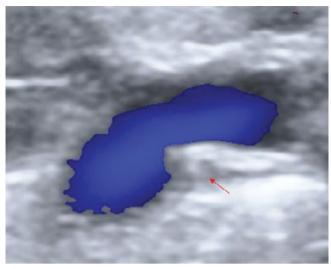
Ultrasonography of the thoracic duct. Thoracic duct (red arrow)
